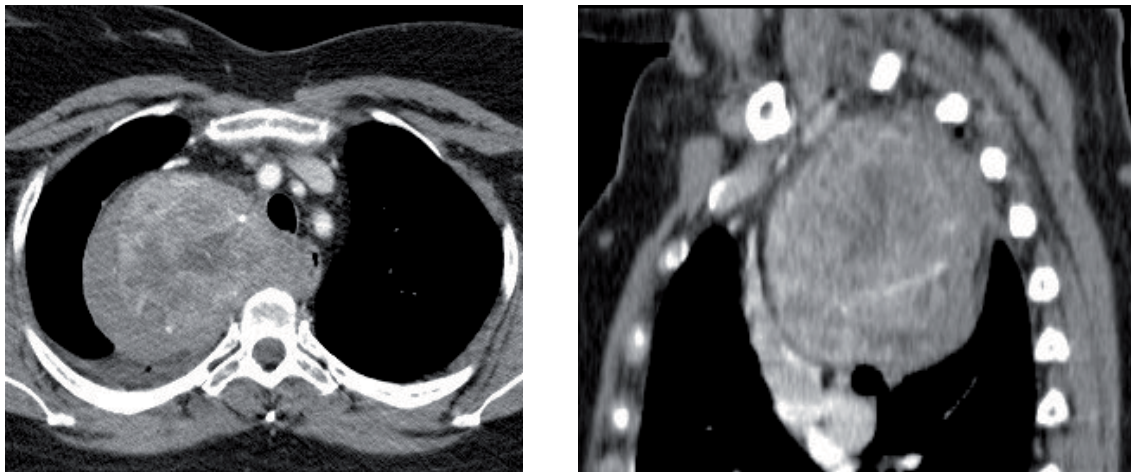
Axial and sagittal views of a CT scan of a goitre growth into the posterior mediastinum.
